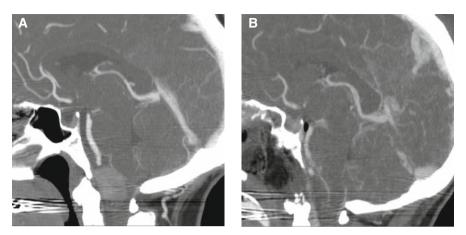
Transodontoid approach for foramen magnum meningioma. Preoperative (A) and postoperative. Reprinted with permission from Prevedello DM, Kassam AB, Snyderman C, Carrau RL, Mintz AH, Thomas A, Gardner P, Horowitz M. Endoscopic cranial base surgery: ready for prime time? Clin Neurosurg 2007 Oct; 54: 48–57. (B) CT angiogram of the head of a 46-year-old woman with an anteriorly-based foramen magnum meningioma who underwent two-stage transodontoid EEA
